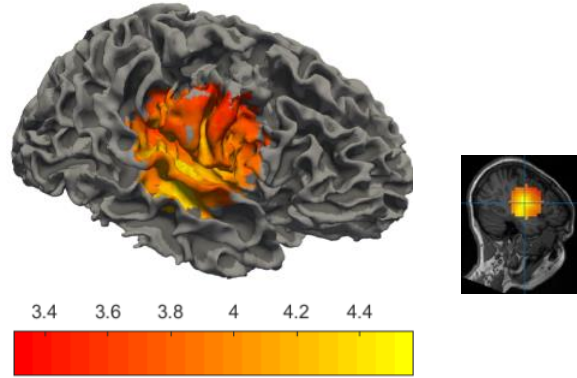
Source localisation for Patient P035 using Solution 1, 2, 3, 4 and validations. (a) Solution 1, (b) Solution 2 and (d) Solution 4 were co-localized to parietal convexity, which are concordant with the propagation of the clinical solutions. (c) Solution 3 with kurtosis value 5.31 localized to left posterior inferior temporal lobe, which is irrelevant with all the validations of this patient. The subfigures of (a), (b), (c) and (d) show the corresponding sources registered onto the MRI images. In the colour maps shown in (a), (b) and (c), yellow represents the highest kurtosis value and red represents the lowest values. (e) The validations used in this study, in which surgically resected areas are indicated by the blue surface and pink discs indicate the clinically localized results. In clinical EEG-MEG source localisation, the onset of the source located at antero-basal temporal cortex then propagate to infero-lateral temporal cortex, later to posterior temporal cortex and parietal convexity. This propagation process is indicated by pink discs with white number 1, 2, 3 and 4 in (e).
